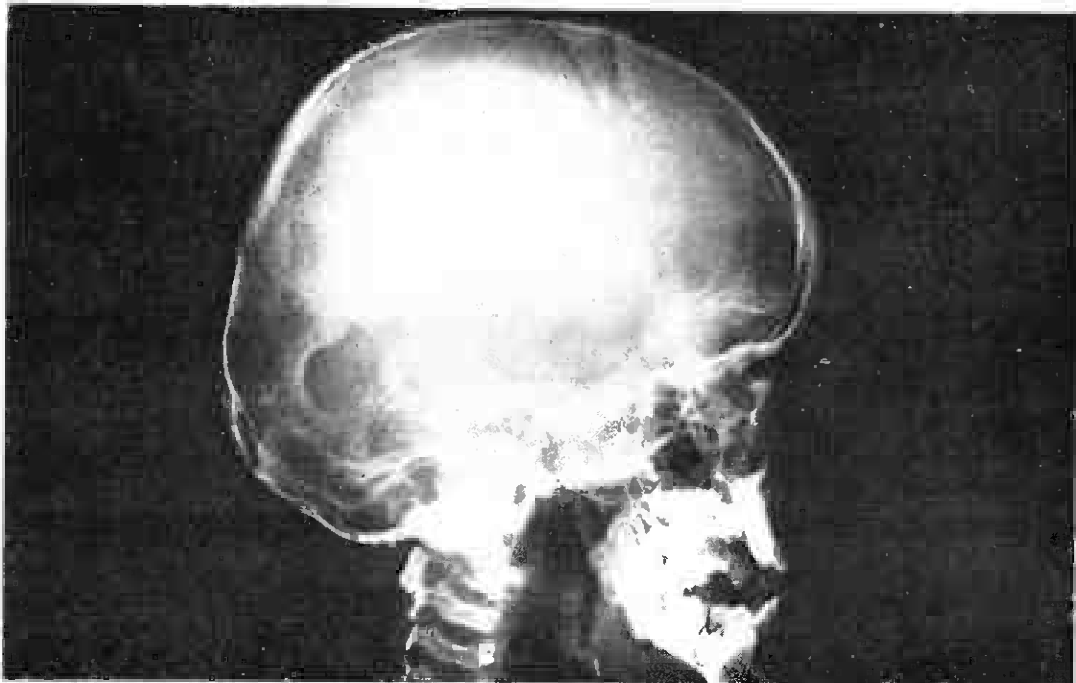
Case 1, X-ray of skull revealed well defined oval defect in occipital parietal region.
